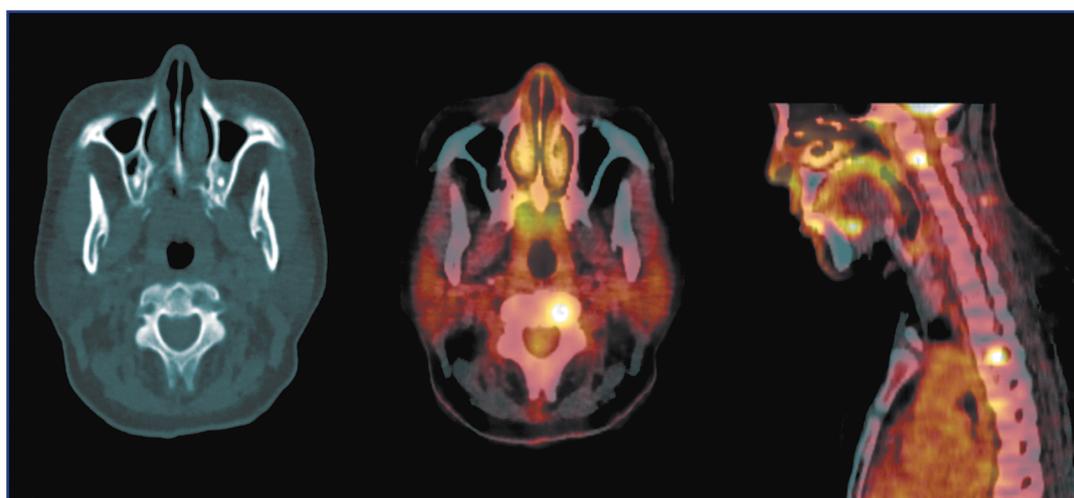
PET/CT. Metastatic lesions of the lateral mass of the C2 vertebra on the left lateral mass of the C2 vertebra on the left.
